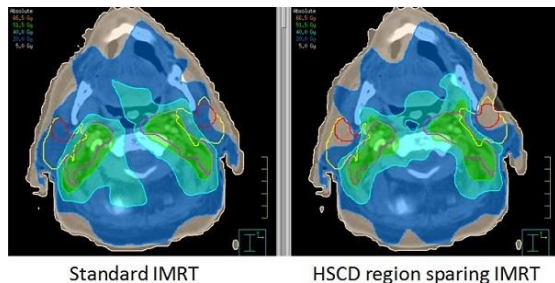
Dose distributions depicted on a CT of a patient with cT3N0 laryngeal cancer using standard IMRT and HSCD region sparing IMRT. The yellow lines are the parotid glands and the red lines are the HSCD regions. With standard IMRT the mean HSCD region dose is 15.8 Gy (right) and 20.6 Gy (left) and with HSCD region sparing IMRT this is 7.4 Gy (right) and 10.8 Gy (left).
